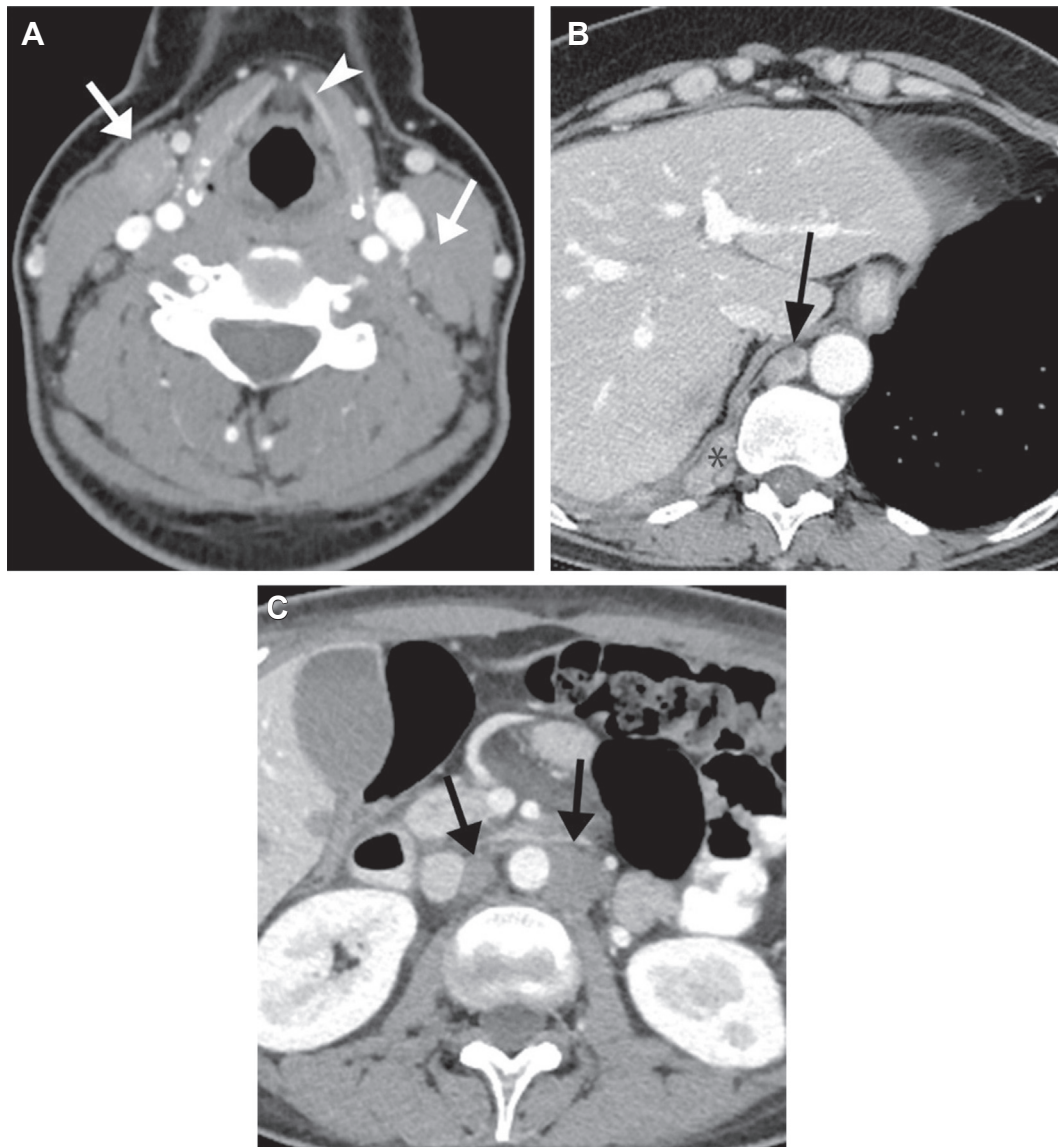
Examples of patients with TET and lymph node metastases considered nonregional (M disease). (A) Axial contrast-enhanced neck CT at the superior margin of the thyroid cartilage (arrowhead) reveals bilateral neck lymphadenopathy (arrows). Locoregional spread in the neck is limited to lymph nodes below the cricoid cartilage level. Involved lymph nodes superior to this are considered M disease. (B) Axial contrast-enhanced CT of the lower chest reveals right retro-crural lymphadenopathy (arrow). Note this lymph node is surrounded by fat and separate from the right pleural metastatic disease (*). Retro-crural lymph nodes are outside of the TET nodal map, and their involvement is considered M disease. (C) Axial contrast-enhanced CT of the upper abdomen at the level of the lower kidney poles reveals bilateral para-aortic lymphadenopathy (arrows). Abdominal and retroperitoneal lymph node involvement is outside of the TET nodal map and is considered M disease. One should carefully insure that soft tissue in this region is separate from contiguous pleural involvement, as in this case. CT, computed tomography; TET, thymic epithelial tumor.
